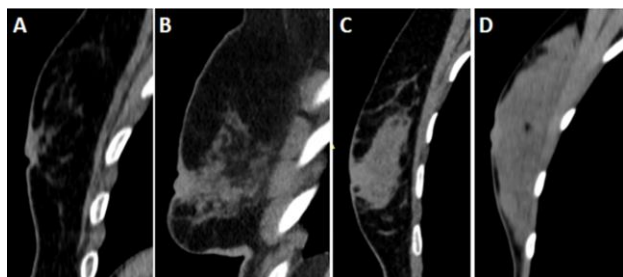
Breast densities on CT images were evaluated using sagittal reformat images.
